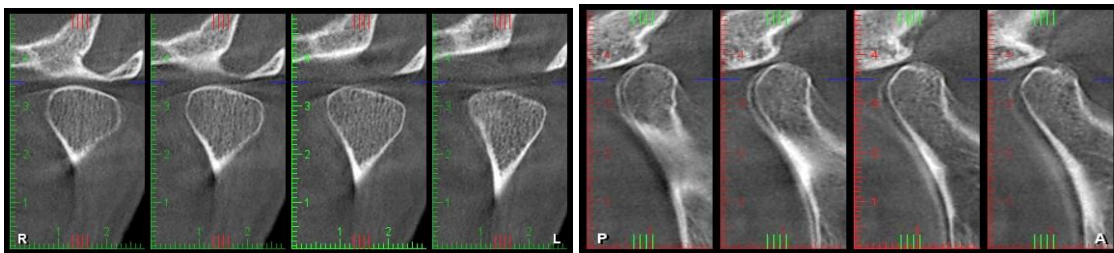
Native CBCT exam sections analyzed in the axial, coronal, sagittal and 3D (case 1)
